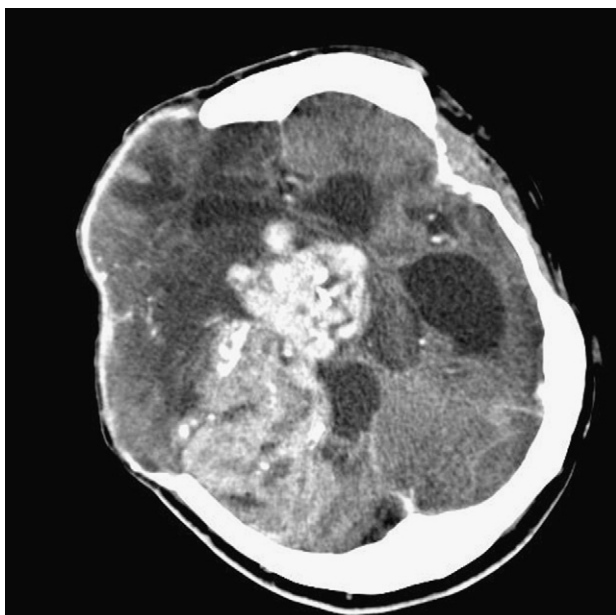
Brain CT with contrast demonstrating local recurrence of the tumor 3 years after surgery.
